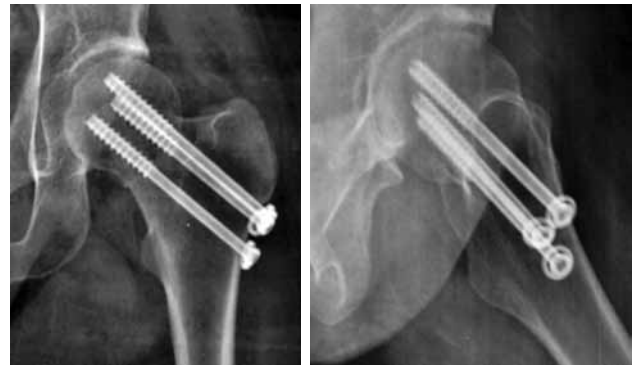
Postoperative anteroposterior and lateral radiographs on second month showing healing fracture of femoral neck.
